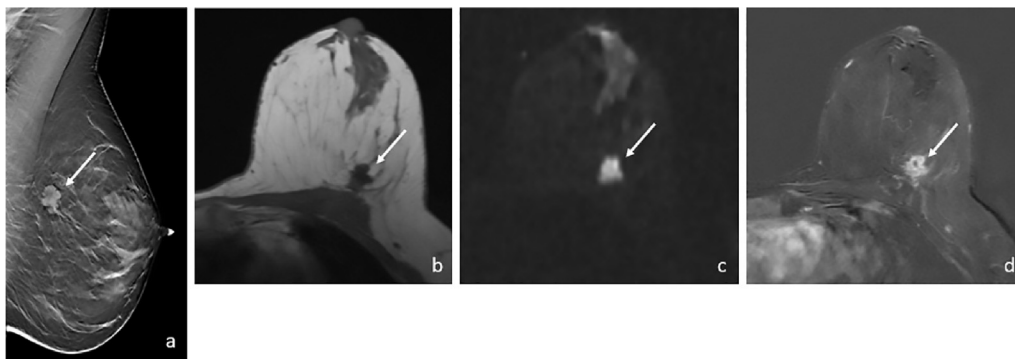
Concordance in assessing cancer between contrast-enhanced magnetic resonance imaging (CEMRI) and unenhanced MRI plus digital breast tomosynthesis (UMRI + DBT) in a 64-years-old patient with unifocal pathology-proven invasive ductal carcinoma. DBT showed a spiculated mass in the left breast, as evident in the medio-lateral oblique view (arrow in a). On UMRI, the mass appeared as a well-conspicuous, spiculated hypointense lesion on T1-weighted transverse imaging (arrow in b), with restricted diffusion on the transverse high b-value image (arrow in c) (apparent diffusion coefficient map not shown). On the CEMRI subtracted T1-weighted imaging (arrow in d), the lesion appeared as a mass with intense contrast enhancement.
